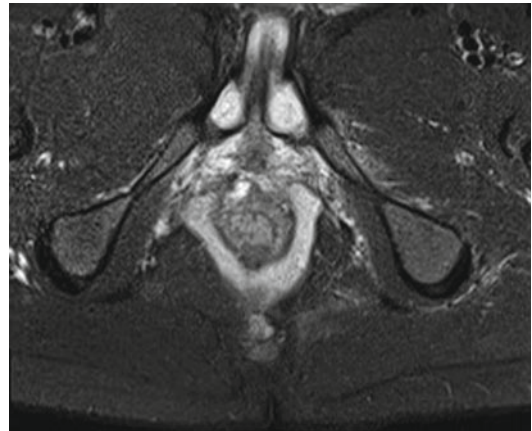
Axial STIR MRI in a patient with a typical horseshoe extension wrapping around both posterior quadrants of the anus
